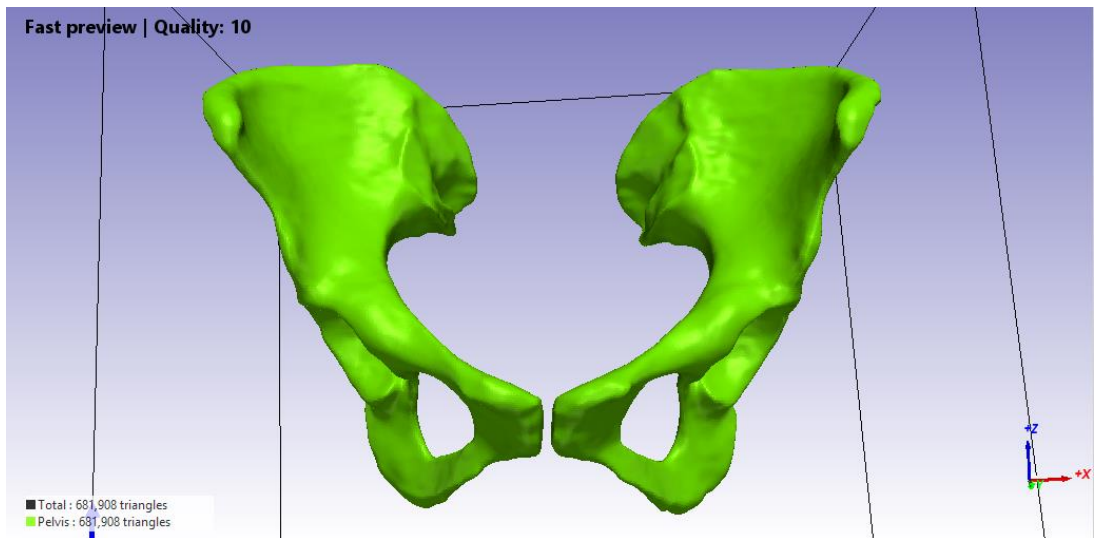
A coronal view of a full pelvis mask in the Simpleware ScanIP software following all of the steps of segmentation and smoothing ready for exporting as an STL file for one of the CT scans used in this study.
